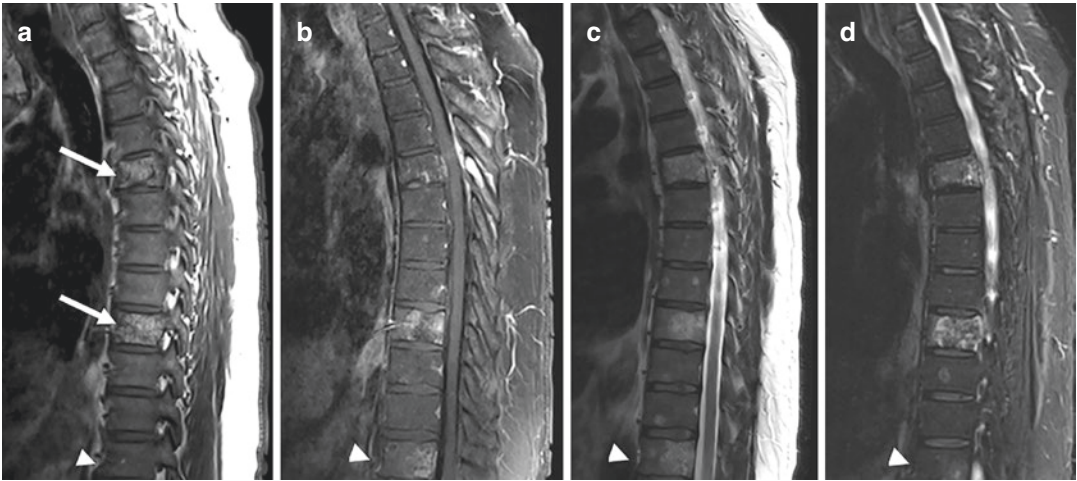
Vertebral hemangioma. (a) Sagittal T1-weighted MRI of the thoracic spine demonstrates heterogeneously hyperintense lesions involving two thoracic vertebral bodies. There are prominent internal trabeculations. (b) These vertebral hemangiomas show variable enhancement on sagittal T1-weighted, contrast-enhanced, fat-saturated MRI. Sagittal T2 (c) and STIR (d) images
